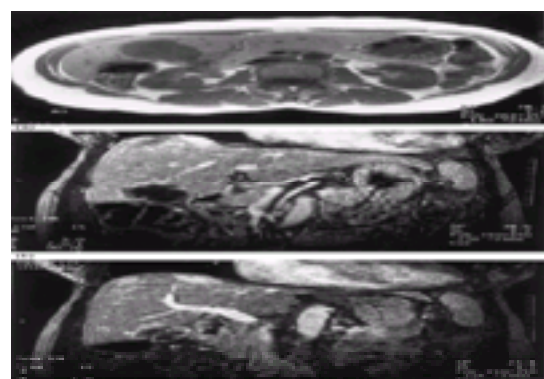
(a) MRI scan demonstrating a mass arising within the gallbladder with extension into the hepatic parenchyma; (b) MR angiogram from the same patient demonstrating the relation between the hepatic artery and the mass; (c) MR angiogram from the same patient showing the relation between the main and right portal vein and the mass.
